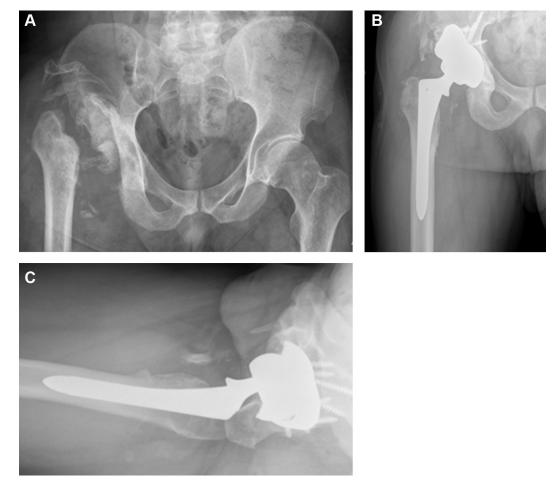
An anteroposterior (AP) radiograph (A) of a 45-year-old male (patient 7) with incomplete paraplegia secondary to cauda equina syndrome with destructive changes in the hip joint consistent with Charcot arthropathy. He underwent a THA with a tantalum acetabular cup, a tantalum augment, and supplemental screw fixation for a Paprosky type 3A acetabular bone defect and a fully coated femoral stem as noted in the AP hip (B) and cross-table lateral (C) radiographs.
